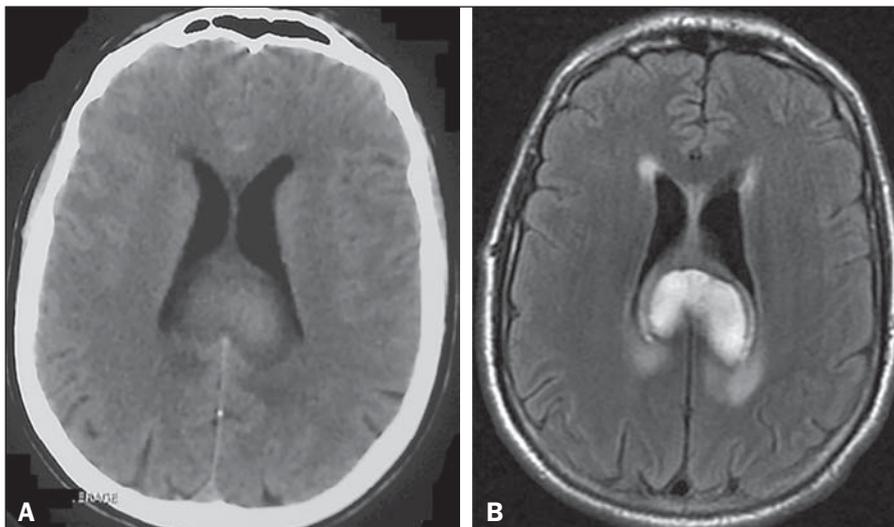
Non-contrast computed tomography (A) and T2-weighted fluid attenuated inversion recovery magnetic resonance imaging (B) demonstrating a large, heterogeneously enhancing mass in the splenium of the corpus callosum, consistent with a focal collection of intraparenchymal blood. No evidence of subarachnoid hemorrhage is apparent.
